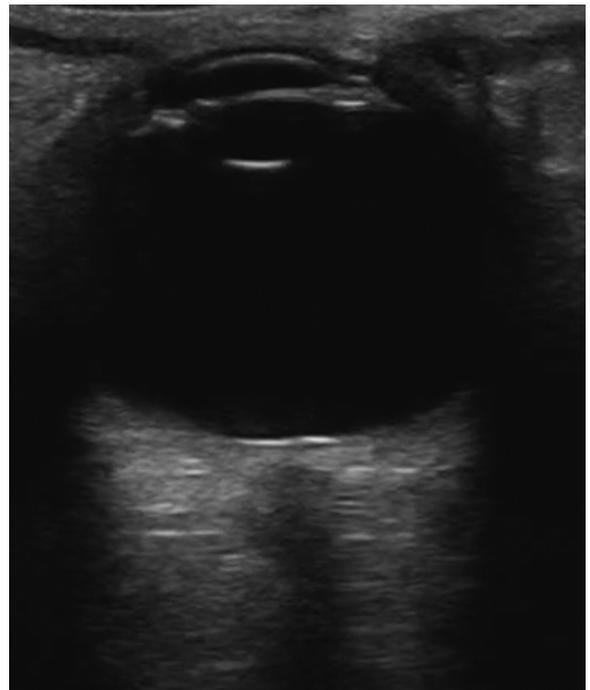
Ultrasound of the right orbit demonstrating normal anatomic features.
